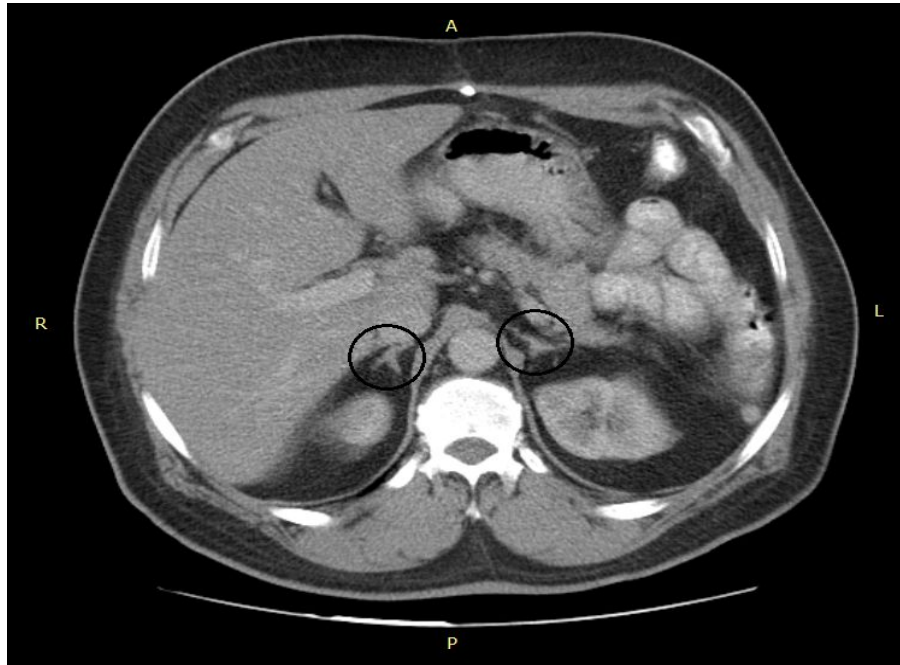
Axial CT image for Female (41 years) shows typical location of both right adrenal gland (V shape) and left adrenal gland (Y shape).
